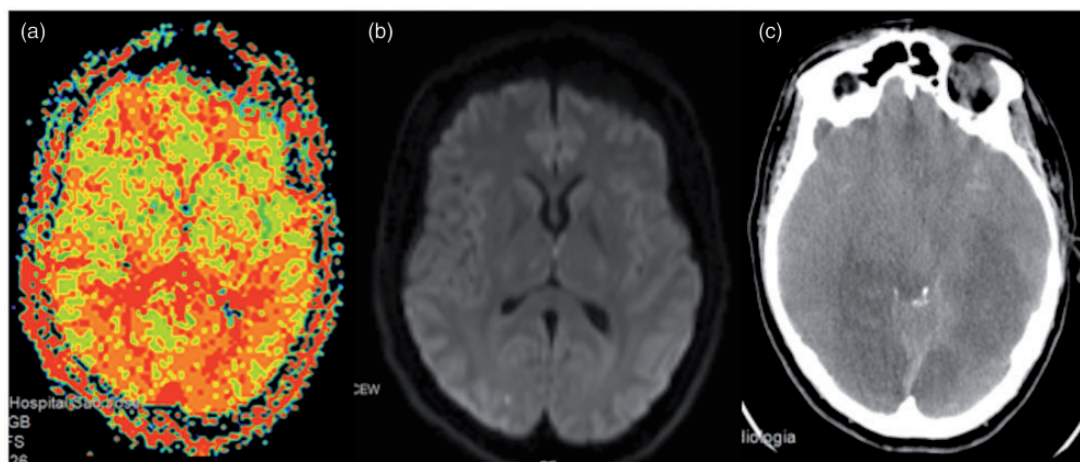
(a) MR perfusion study showing increased TTP (red and orange) in the left temporal lobe (middle cerebral artery territory) and in both occipital lobes (posterior cerebral artery territory) on the first 24 h after SAH. (b) DWI performed on the same day shows small punctate acute ischemic lesions and no territorial infarction on the hypoperfused areas. (c) CT scan ten days after showing acute ischemic lesions due to severe vasospasm, affecting the hypoperfused territories.
